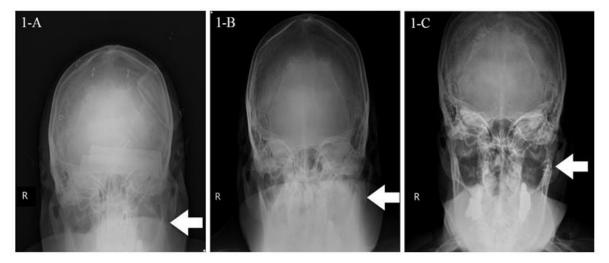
Simple skull radiograph with modified Towne's projection
